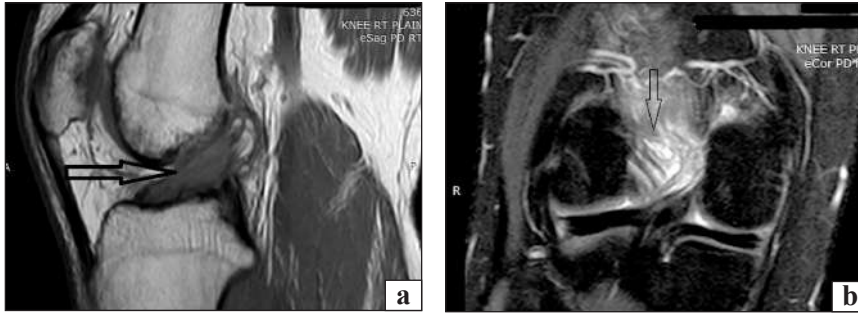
(a) MRI reveals an aberrant signal in a bulky ACL on both T1-weighted, (b) T2-weighted imaging
